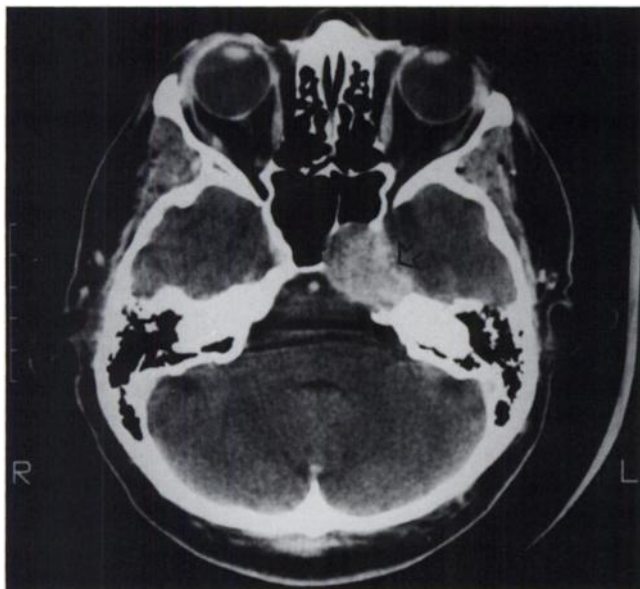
Contrast-enhanced transaxial CT scan demonstrates a homogeneously enhancing mass (arrow) with extension of the tumor into the sphenoid sinus and bony erosion of the petrous apex.
